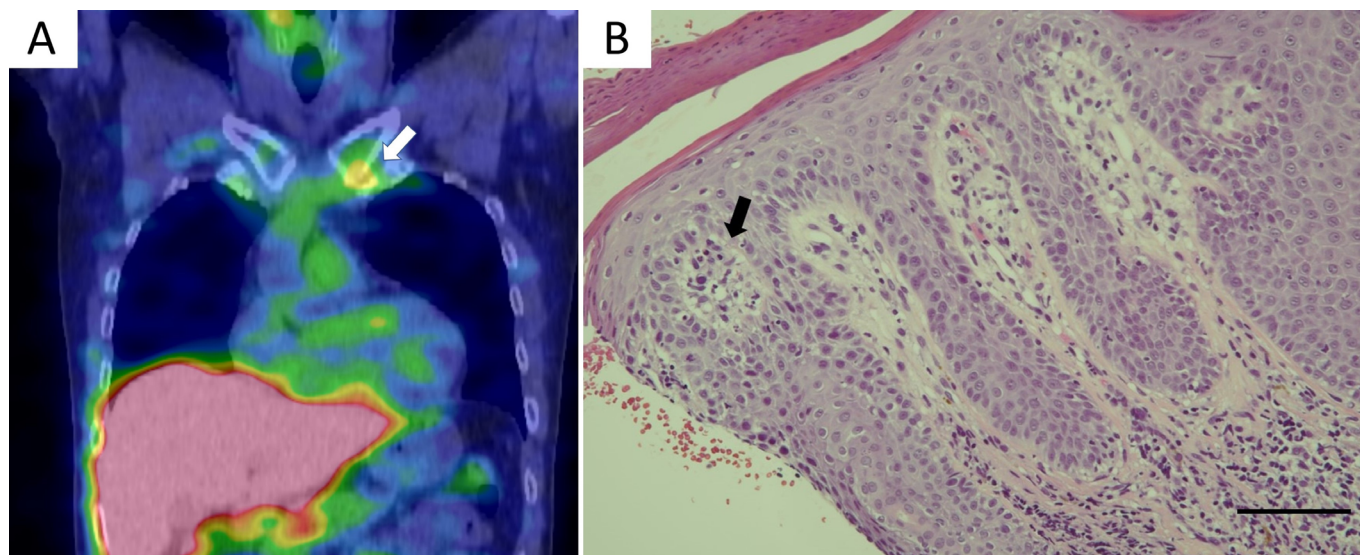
(A) Gallium scintigraphy revealed increased uptake in the left sternoclavicular joint. (B) Skin biopsy of the head erythema revealed parakeratosis and microabscess leading to the diagnosis of psoriatic arthritis (PsA).
